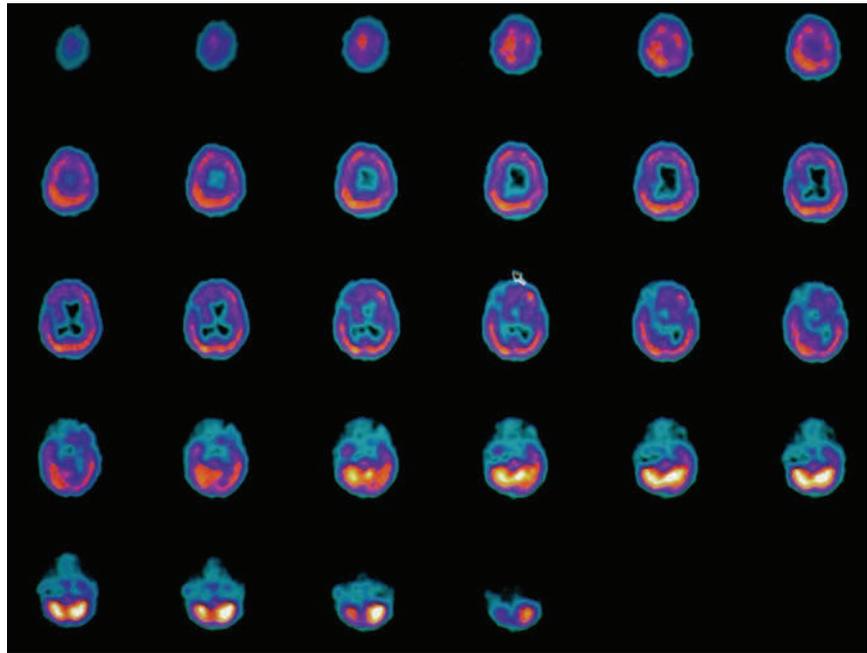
(a) HMPAO SPECT' brain imaging, transverse slices, 4 months and 80 HBO's following Fig. 20.9a. Note persistent increase in perfusion to the frontal lobes. (b) Frontal projection three-dimensional surface reconstruction of Fig. 20.9a
